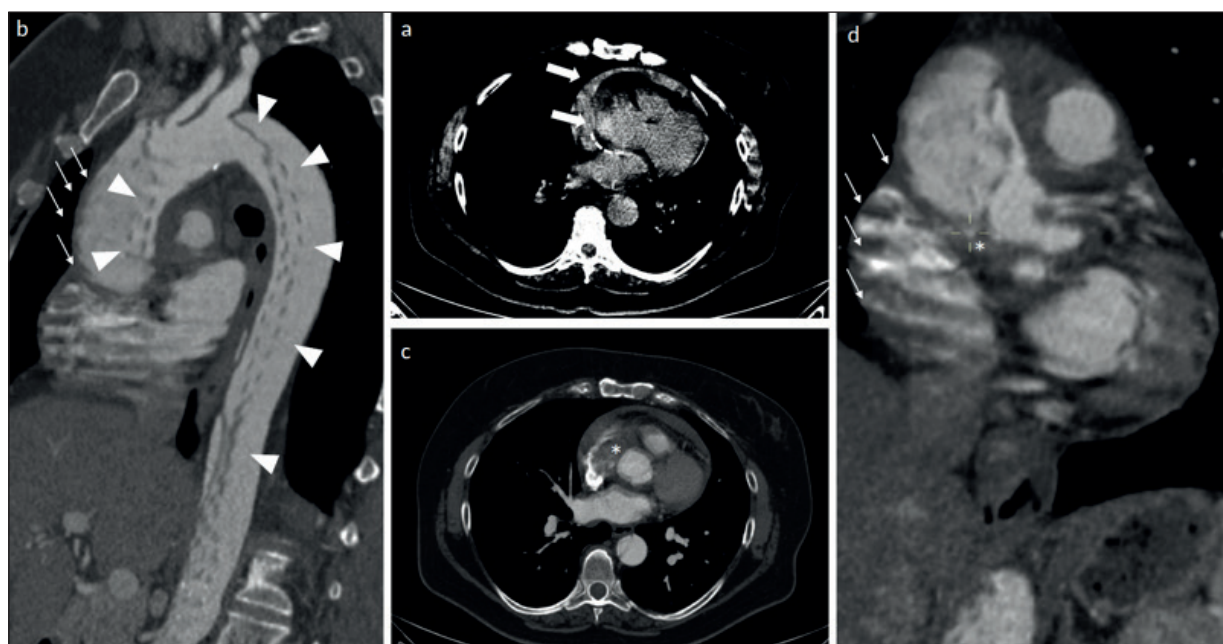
Patient underwent CT for epigastric pain and abdominal tenderness. Cranial scans (image a) reveal high-attenuated area of the aortic profile, and high-attenuated pericardial fluid (thick white arrows and dashed curved line). The exam was urgently completed with a non-optimized CTA of the aorta (image b), which shows a type AAD (white arrowheads). CTA shows severe pulsatility artifacts (thin white arrows). In images c) and d), a focal arterial blush-like image seems appreciable under the aortic root (white asterisks). The blush-like image was interpreted as a suspected aortic rupture, however poorly characterized given the non-optimized technique. The patient urgently underwent aortic surgery, which confirmed all the CT findings. Abbreviations: CT: computed tomography; CTA: computed tomography angiography; AD: aortic dissection.
